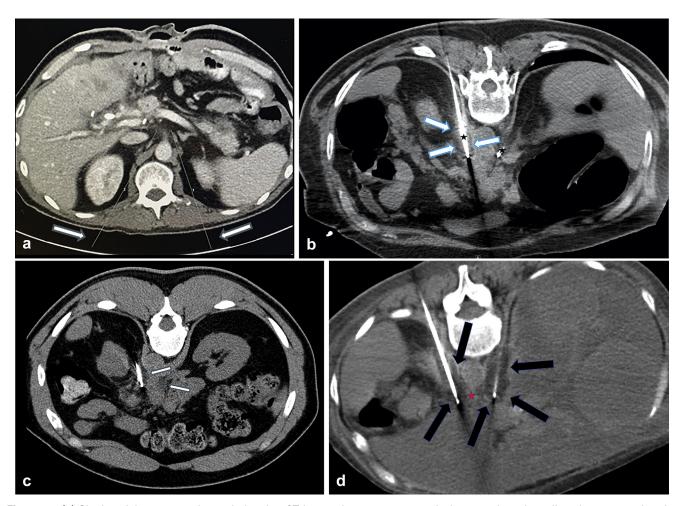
(a) Single axial contrast enhanced planning CT image demonstrates a typical approach to the celiac plexus, targeting the anterolateral aorta at the level of the celiac artery (arrows). (b) Single axial intraprocedural CT image at the level of T12 demonstrates two 17-gauge cryoablation probes (stars) advanced to the celiac plexus. The hypoattenuating ablation zone is outlined by arrows. (c) Second single axial CT image slightly above the level of the cryoprobes demonstrates the hypoattenuating ablation zone occupying the target region ([a] arrows). (d) Single axial intraprocedural image from a different patient at the level of the celiac artery (star) demonstrates coverage of the expected location of the celiac plexus network by hypoattenuating cryoablation zones bilaterally (arrows).
